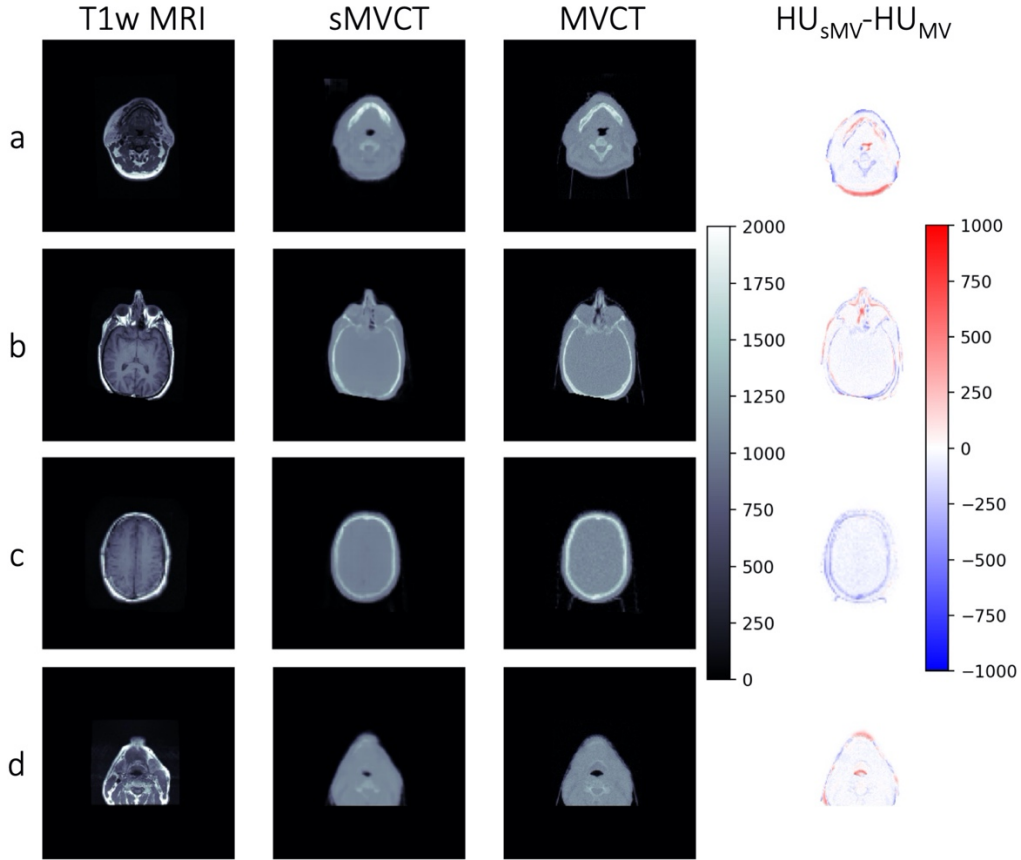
Results of MRI to synthetic MVCT
